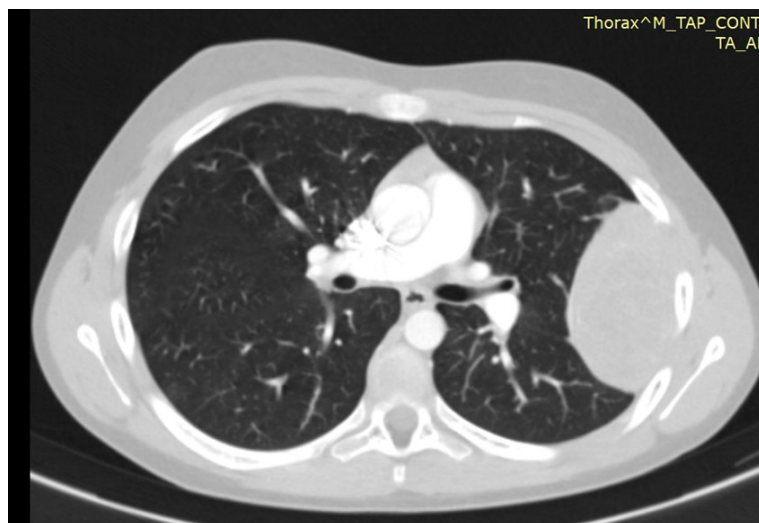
Chest CT Showing the Second Pleuro-Pulmonary Recurrence in the Left Lung
